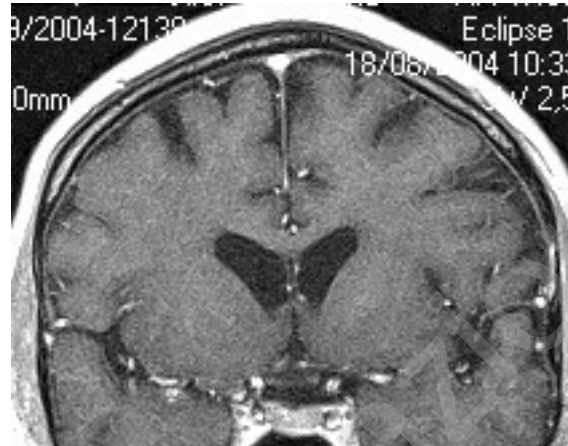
Coronal contrast-enhanced T1-weighted MR image shows no pathological changes within suprasellar region. Optic chiasm is still normal; regression of the lesion previously seen.
